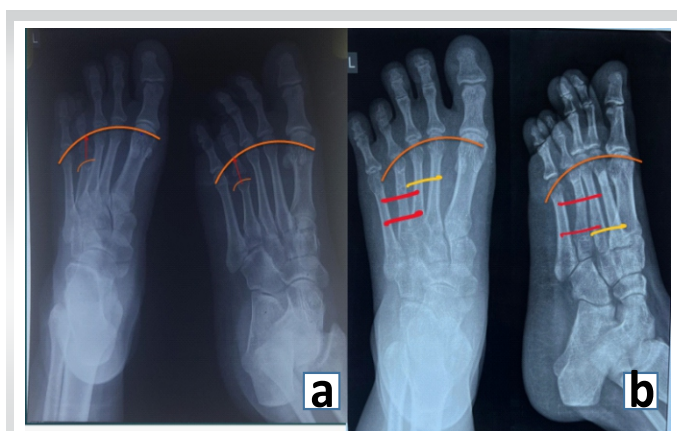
X-ray after 6 months. (a) Left foot anterior posterior view and oblique view with metatarsal lengthening of 2 cm. (b) Left foot anterior posterior view and oblique view with arch of parabola achieved with metatarsal lengthening of 2 cm.
